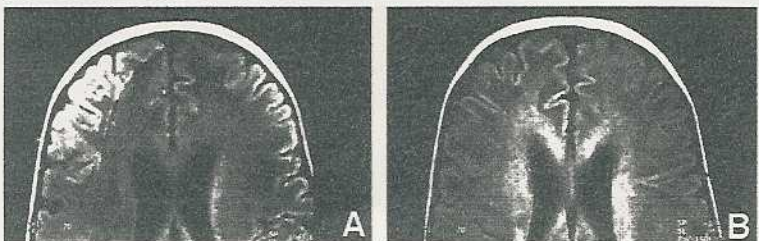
Representative coronal T1-weighted MRI images of L.K. at baseline (A) and at 12 months after gene transfer (B).
